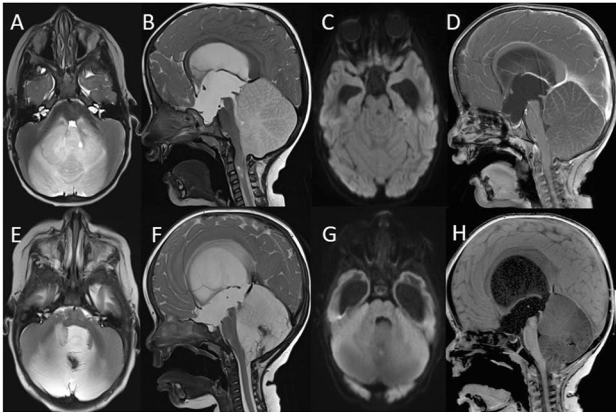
Case 1 A-D; Case 2 E-H. A,E: Axial T2-weighted sequence demonstrates diffuse expansile region of increased T2 signal involving the vermis and medial aspects of the cerebellar hemispheres extending into the middle cerebellar peduncles. There is cerebellar tonsillar descent in both cases and a small syrinx at C2/3 in case 1 B,F. Compression of the 4th ventricle is more marked in Case 2. Small focus of susceptibility inferiorly in Case 2, presumably reflects haemorrhage. B,E,F: Sagittal T2-weighted sequence demonstrates diffuse expansion of the cerebellar vermis. Compression of the 4th ventricle and distension of the third and lateral ventricles is noted in both cases – more marked in Case 2. Small focus of susceptibility inferiorly again noted in Case 2. C,G: No restricted diffusion on DWI. D,H: Midline Post Contrast T1-weighted sequence revealing absence of tumour enhancement. Ventricular changes are again noted.
